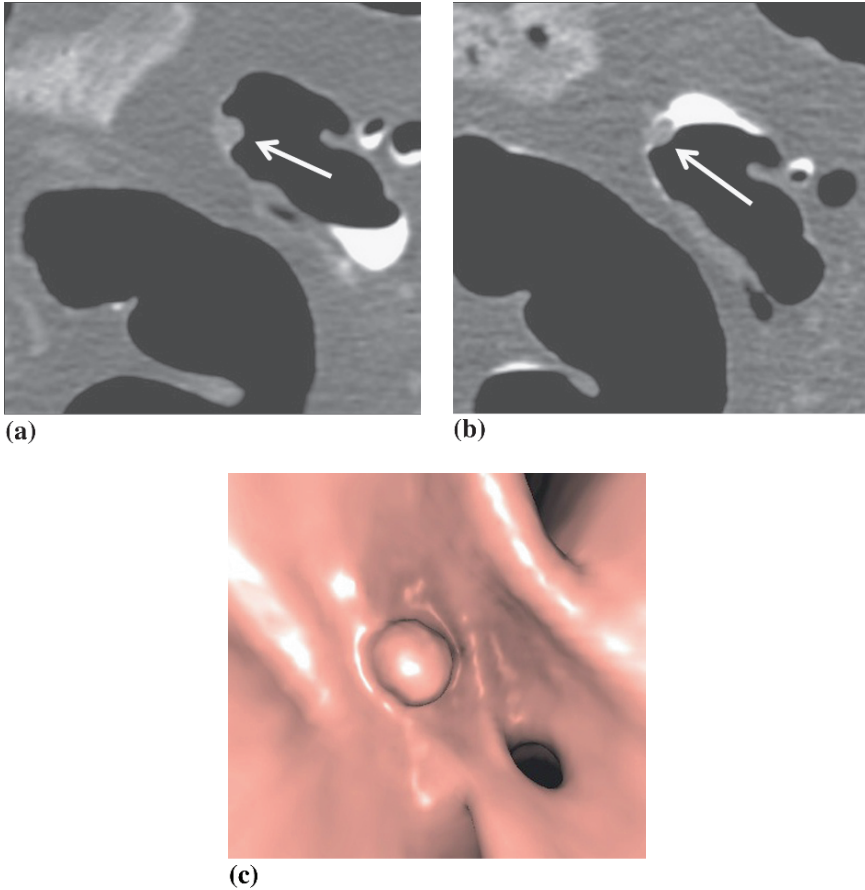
8 mm sessile polyp seen on CT colonography. The broad-based polypoid lesion does not modify its location between the supine (a, arrow) and prone (b, arrow) positions. Note gravitational change in position of high density, iodine-tagged fluid. The endoluminal 3-D volume rendered image (c) confirms the sessile morphology of the polyp
